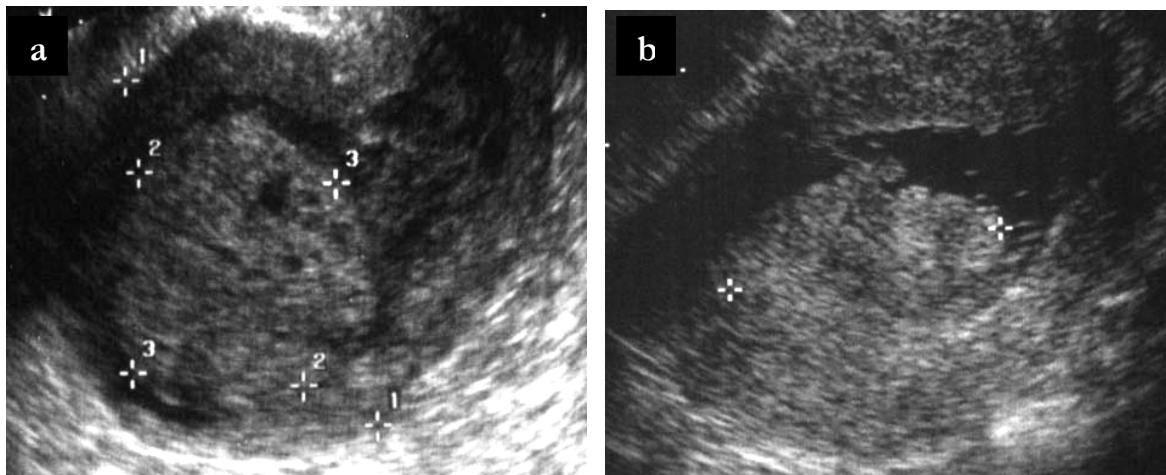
(a) endometrial cancer at conventional ultrasound; (b) endometrial cancer at hydrosonegography
